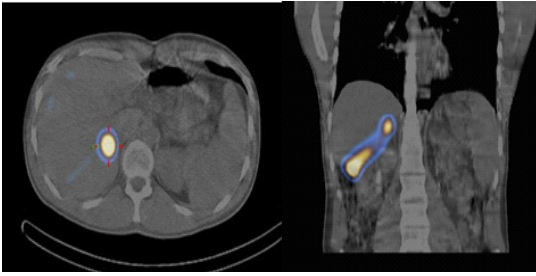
SPECT/CT after selective injection of ^{99m}Tc -MAA in axial (A), and coronal (B) plane demonstrates good targeting of the tumor, no extrahepatic uptake.
